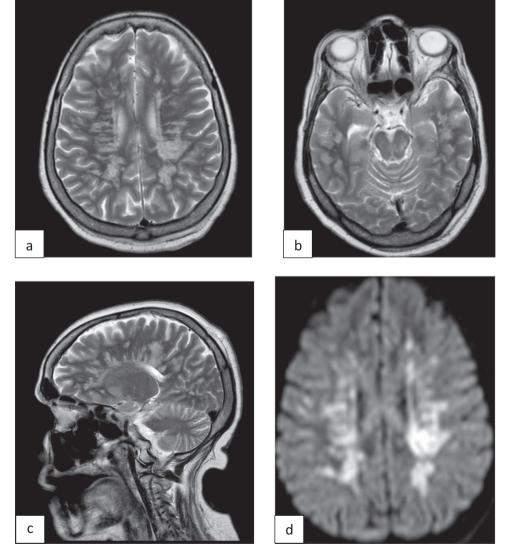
a) Axial T2WI showing diffuse periventricular white matter lesions, b) Axial T2W1 showing midbrain and temporal lobe white matter lesions, c) Sagittal T2WI showing periventricular dawson finger like white matter lesions in ADEM mimicking MS, d) Axial DWI showing bilateral symmetrical periventricular lesions.
